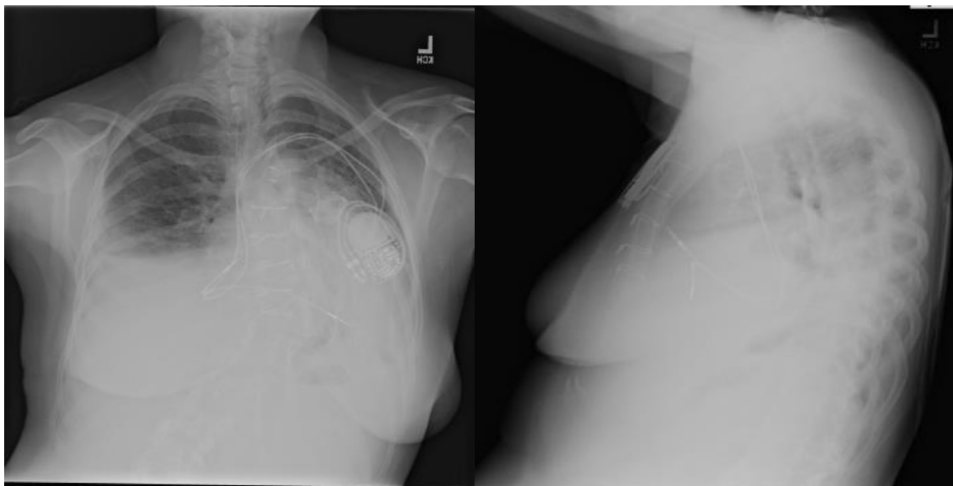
Chest radiograph, posteroanterior and lateral view. No evidence of macro-dislodgment of the pacemaker leads is seen.
